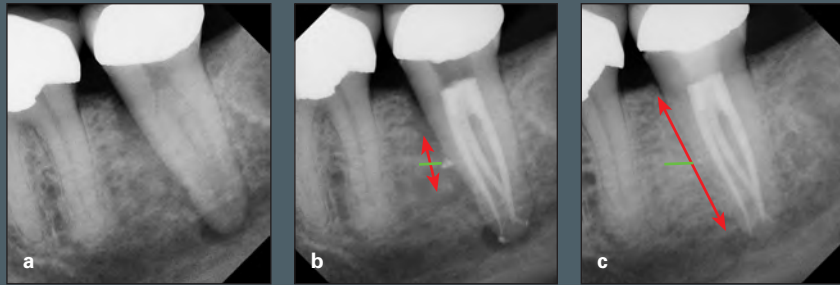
(a) A preoperative apical pathosis accompanied by lateral periodontal breakdown. (b) After treatment with bioceramic sealer and a lateral canal adjacent to the cervical periodontal bone loss. The *red arrow* designates loss of bone on the mesial surface of the molar. (c) Postoperative radiograph showing healing periapically and periodontally. The *green line* indicates the lateral canal. The *red arrow* designates loss of bone on the mesial surface of the molar. (c) Postoperative radiograph showing healing periapically and periodontally. The *green line* indicates the lateral canal. The *red arrow* shows the regeneration of bone adjacent to the root.
